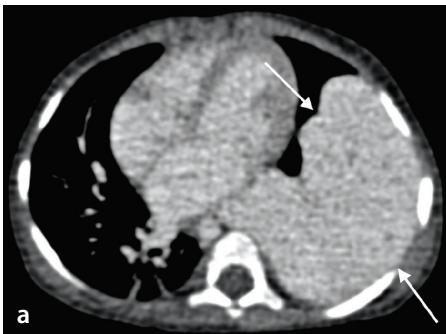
(a, b) A nine-month-old girl with hemangioma. (a) The axial contrast-enhanced computed tomography (CT) image shows large, homogenous contrast-enhanced tumor in the left lower lobe (arrows). (b) Following one year of propranolol treatment, a contrast-enhanced chest CT showed a significant decrease in the overall tumor size (arrows).
